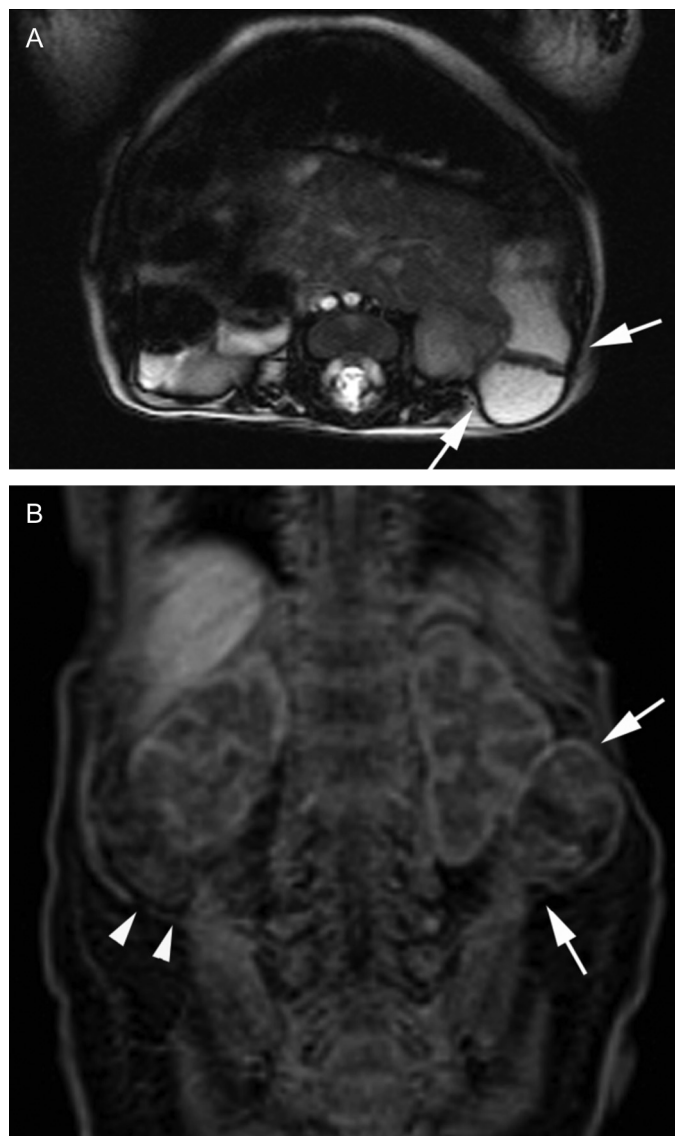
Lumbar hernia on MRI at age of 5 weeks. Axial T2-weighted image (A) and axial reformatted T1-weighted image (B) of abdomen revealed herniation of a fluid-containing bowel loop through the left posterolateral abdominal wall (arrows in A and B), probably via the inferior triangle. Note the normal lower lumbar triangle on the right side (arrow heads in B). Also note the diffusely decreased muscle bulk in abdominal wall and paraspinal regions. Herniated kidneys are not captured in this image.
